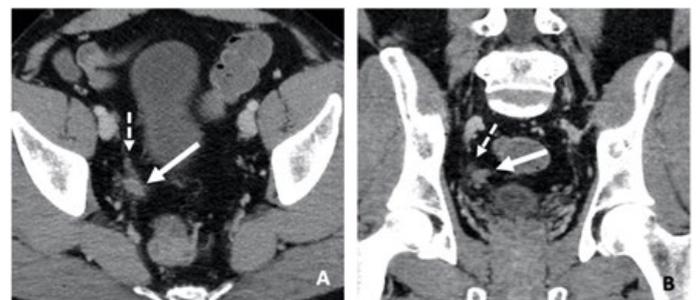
A & B: Axial and coronal images of a CT Enterography performed 18 months earlier showing the lesion (thick white arrow) as an ill-defined soft tissue density within the retroperitoneal fat adjacent and distinct to the right distal ureter (thin dashed arrow). This was distinct from the right seminal vesicle.
